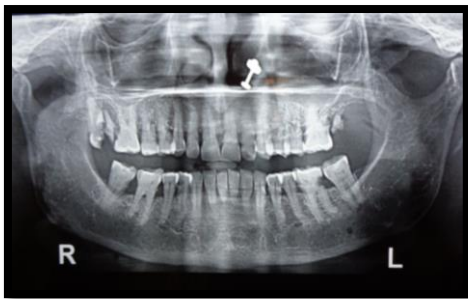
Orthopantomogram revealed a large radiolucency at the periapical region and broken cusp in relation to maxillary right second molar
